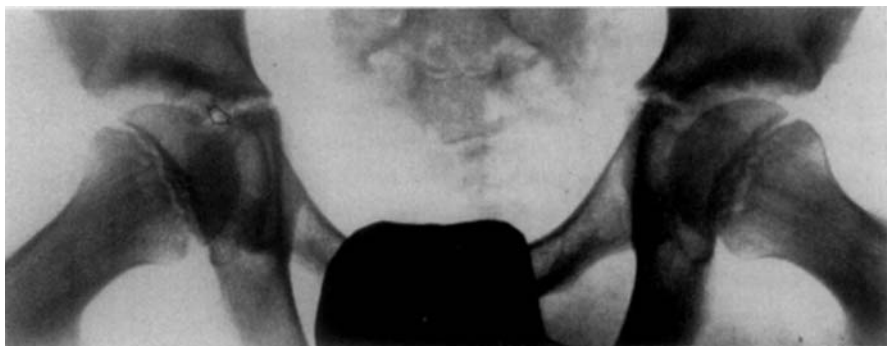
Case 124, boy aged 10. The radiograph was taken four months after intermittent limping and pain in the right hip. The only radiological sign is a small subcortical strip-shaped translucent area proximally in the epiphysis on the lateral view. Complete healing occurred without any other treatment than refraining from athletics and gymnastics for some weeks.
